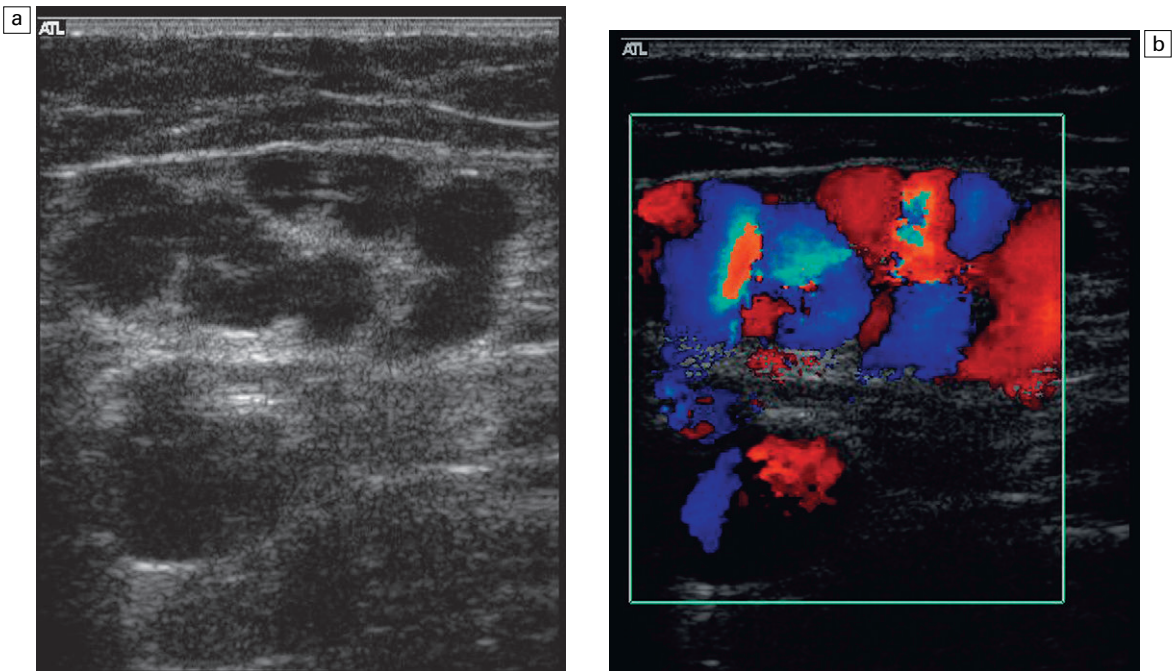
Collateral channels at the saphenofemoral junction on colour Doppler (a) B-scan image; (b) colour Doppler image.
